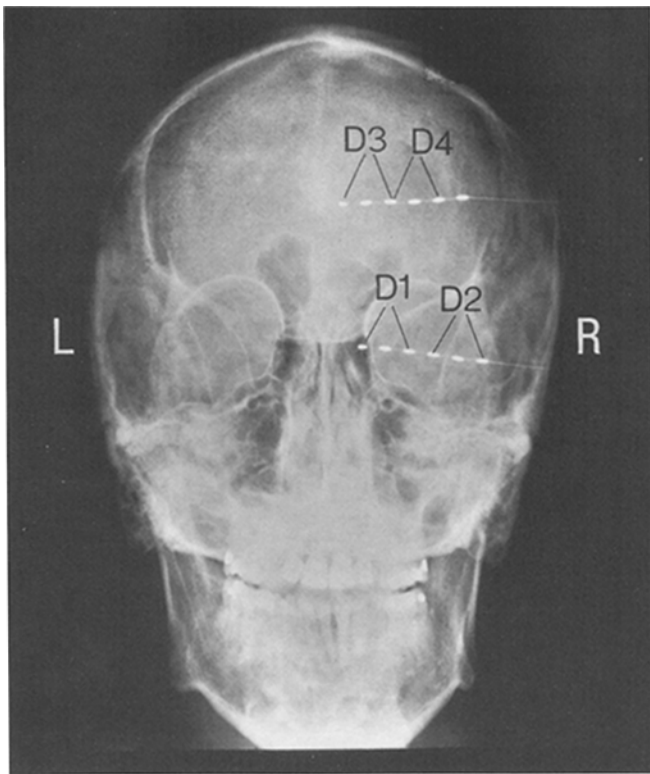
X-ray of one of the three patients in the MIT-Beth Israel study showing a typical example of depth electrodes in the brain. Six electrodes can be seen on each of the two catheters. D1, D2, D3, and D4 are the four dipoles, where each is due to the pair of electrodes indicated.
